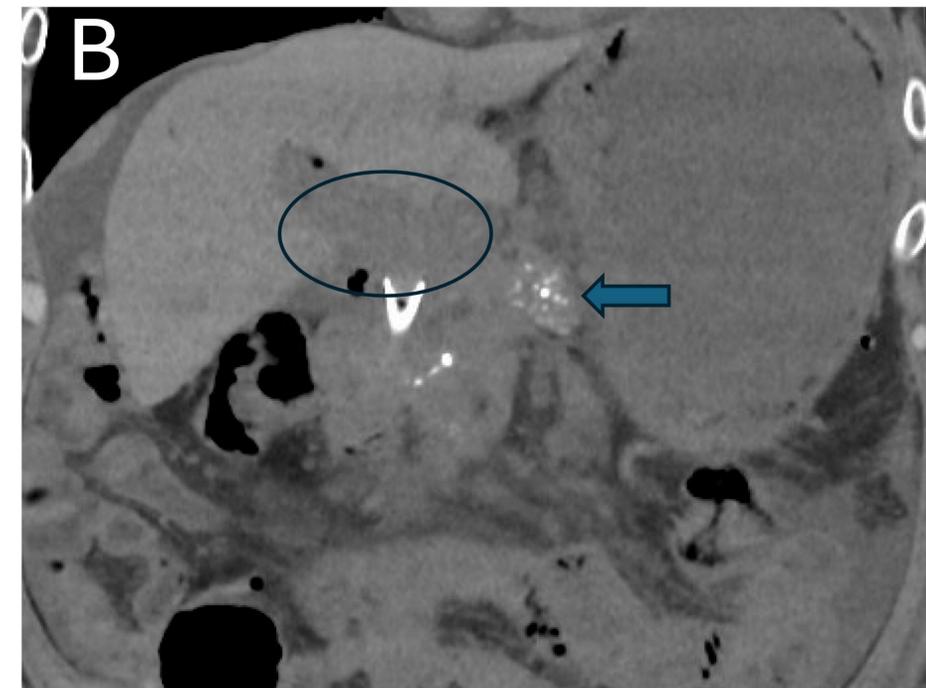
CT without contrast in coronal view. Pancreatic calcifications (arrow) and area of fibrosis extending from pancreatic head (oval). Proximal portion of common bile duct stent also seen in A and B
